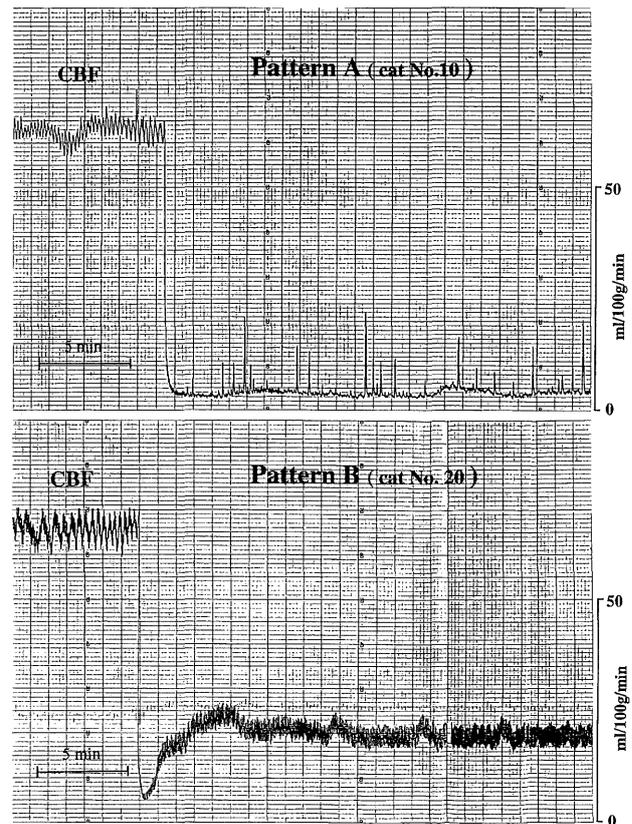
The cortical flow patterns by laser-Doppler flowmetry after middle cerebral artery (MCA) occlusion.
